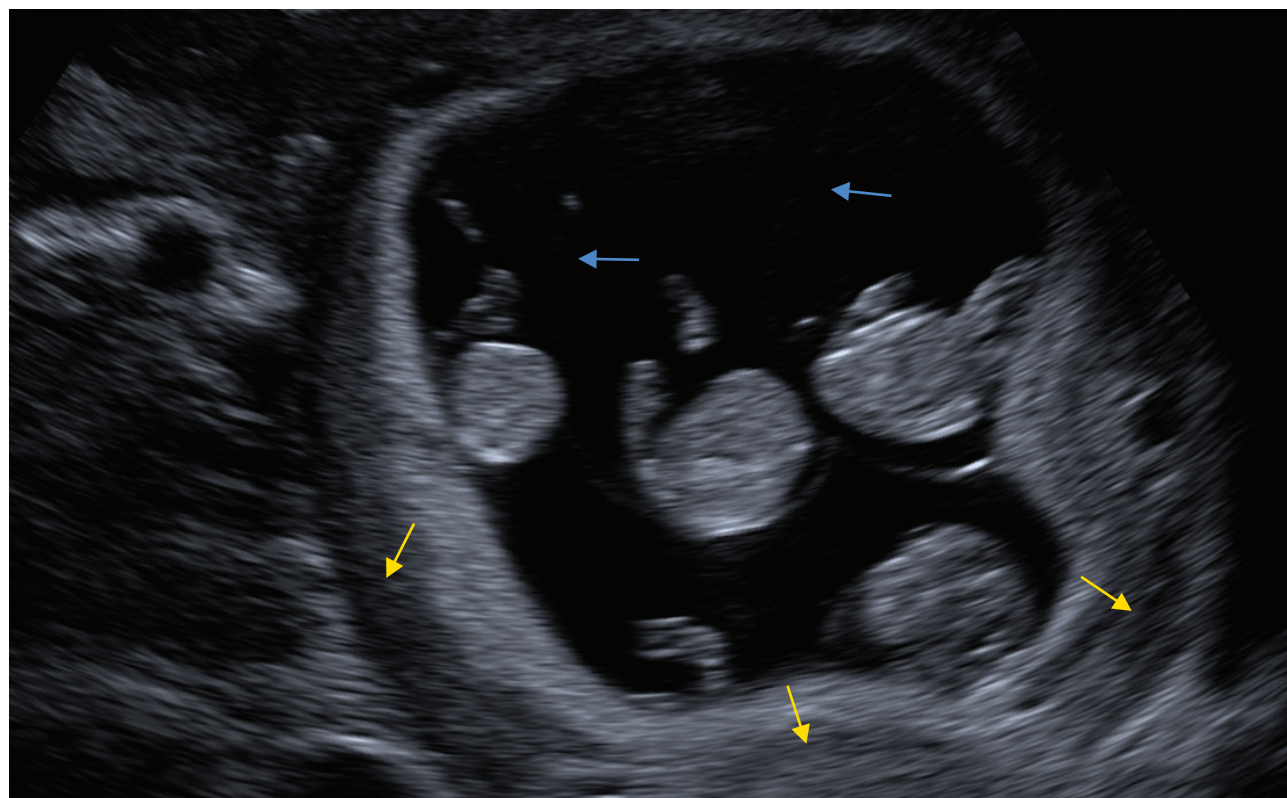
Ultrasound imaging of a monochorionic quadramniotic pregnancy with a common placental mass (yellow arrows) and thin amniotic membranes (blue arrows)
